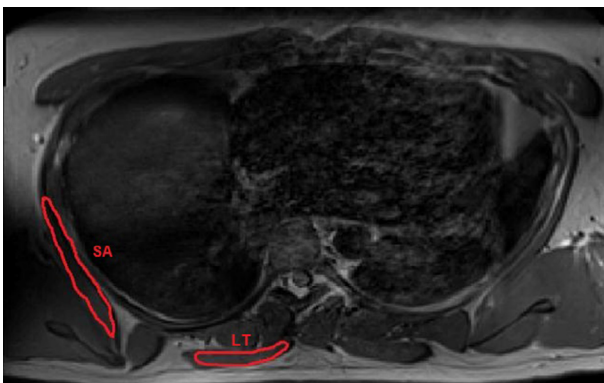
Region of interest (red outline) for the serratus anterior (SA) and lower trapezius (LT) muscle in the T2-weighted (T2 map) image at the level parallel to T6-T7.
